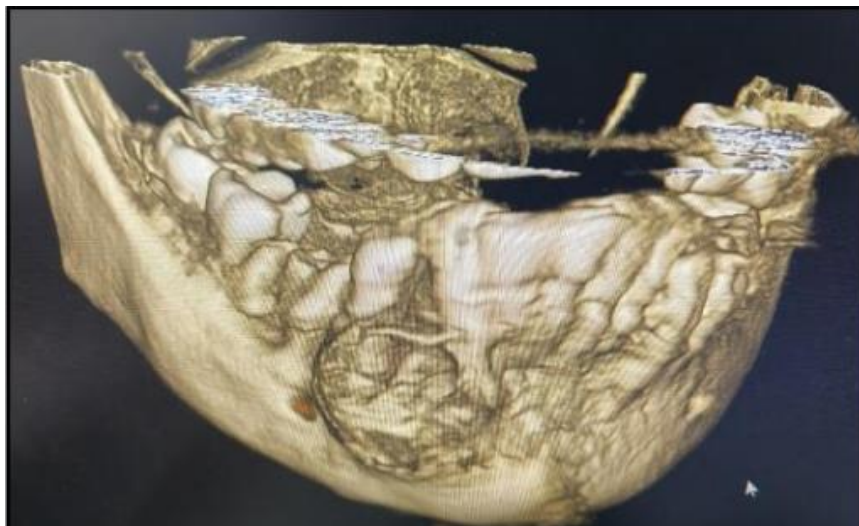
3d computed tomography shows multiloculated, well demarcated lesion in right mandibular body
